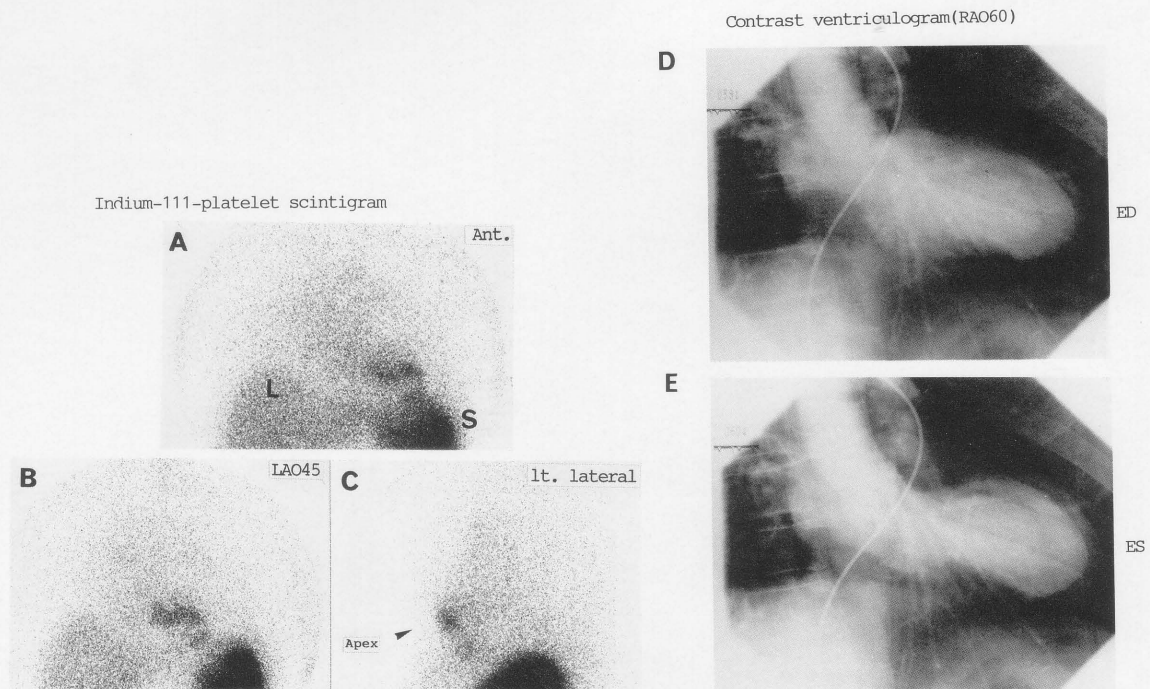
Broad anterior infarction, left ventricular aneurysm (K.T. 57-year-old male). Indium-111 scintigram obtained 48 hours after injection of the labeled platelet suspension shows active thrombus in a large apical aneurysm (panels A, B and C). Contrast ventriculogram (D: End-diastolic phase, E: End-systolic phase) shows apical aneurysm and mural thrombus, L: Liver, S: Spleen.
